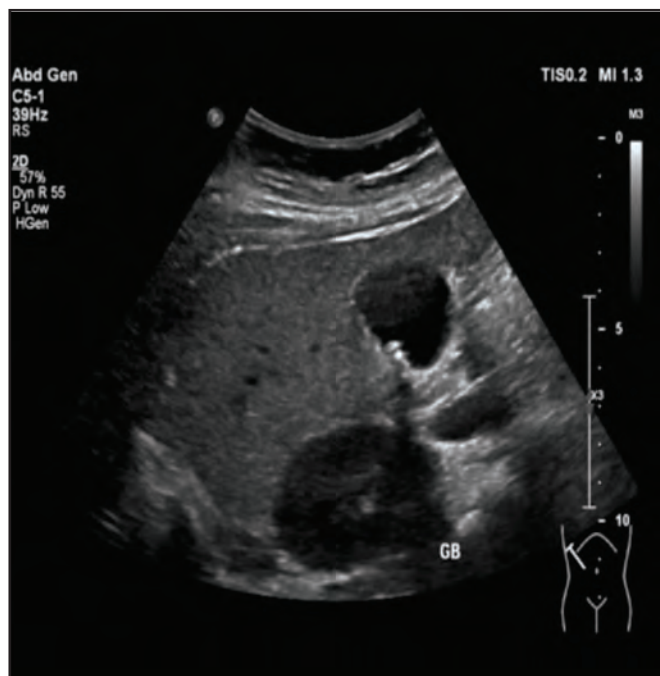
Ultrasound hepatobiliary showed several small calculi within the gallbladder
